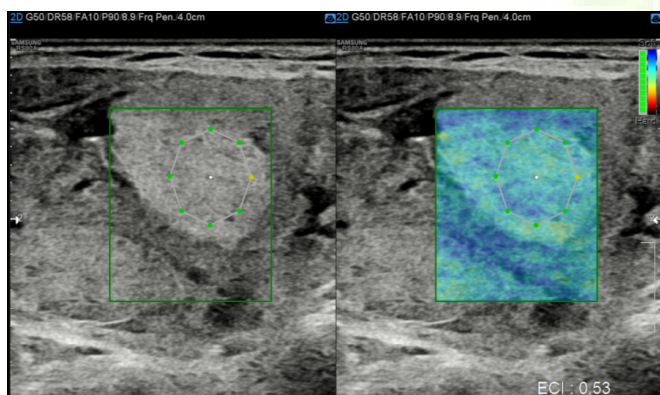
A 45 year old female patient whose ultrasound had spongiform hyperechoic nodule with regular margins, Ragos criteria 2, ECI 0.5, on FNAC, it is Bethesda category 2 and FNAC, it is a colloid goitre
